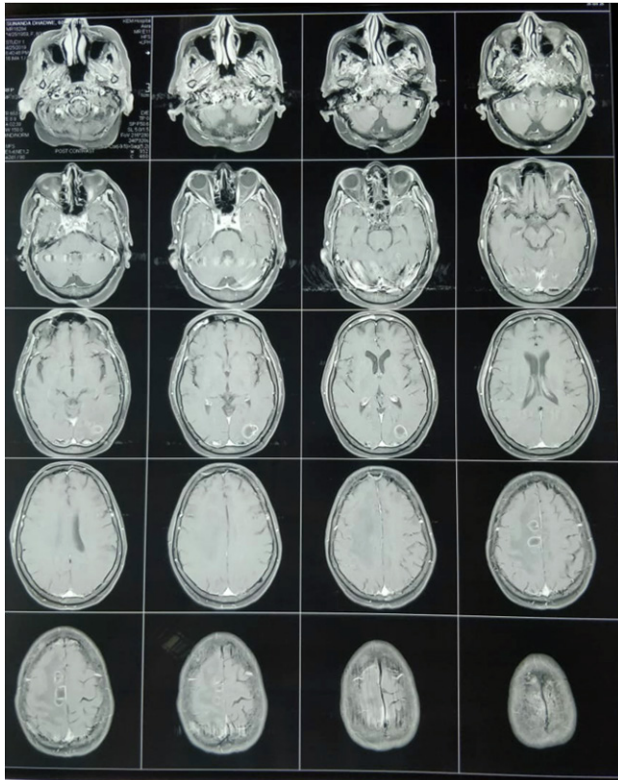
MRI Brain-Lesions in right parafalcine region, right occipital region showing peri-lesional edema and diffusion restriction on DWI
